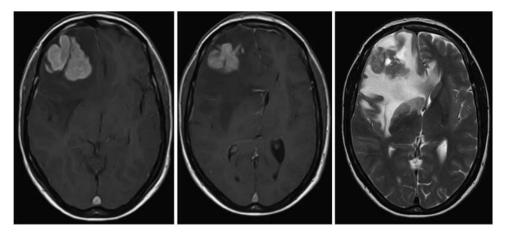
Brain magnetic resonance imaging (MRI) on admission showing a single large contrast-enhancing intracerebal lesion (left, middle) with massive perifocal oedema (right) in the right frontal lobe.
